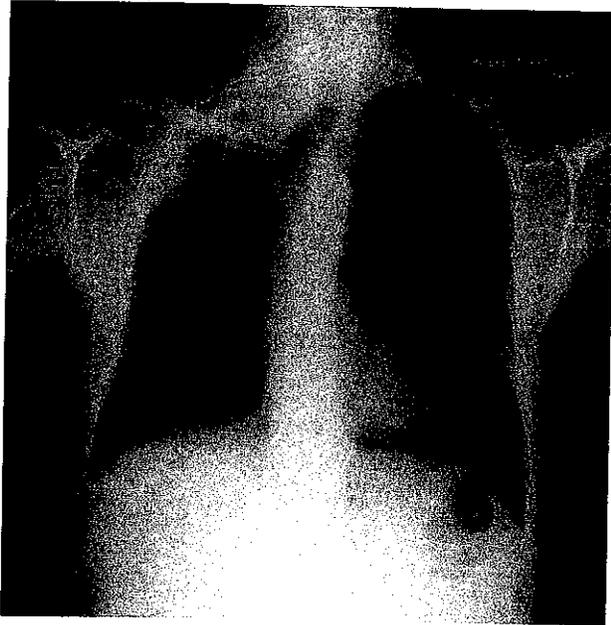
Chest X-ray demonstrating pneumonic destruction of the right upper lobe.
